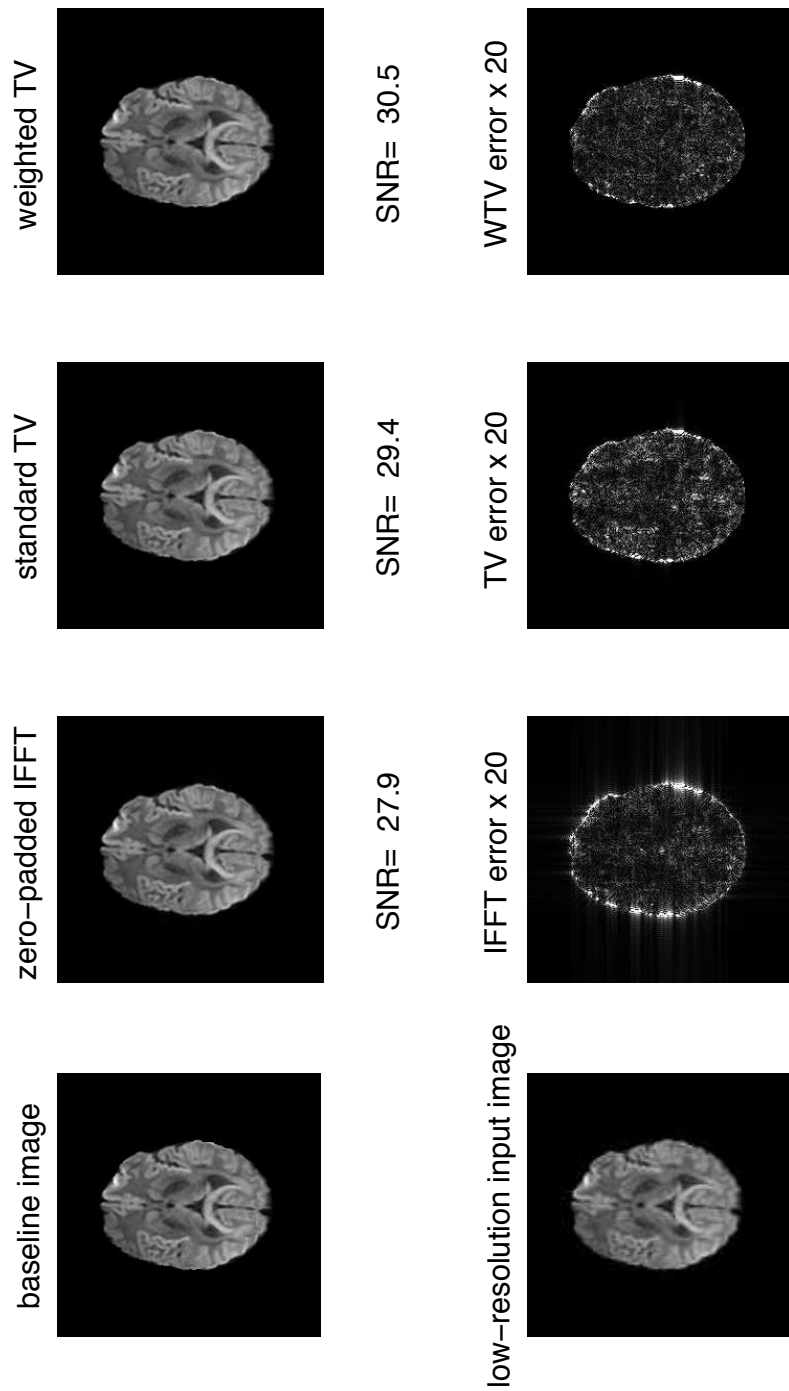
Reconstructed first gradient component of a typical DWI subject using 3 different methods. The SNR value is provided for the result of each method demonstrated in the first row. The second row shows the low-resolution image, by a factor of 2, and the difference image between each reconstructed image and the original high-resolution baseline image, that is magnified by 20 times. The higher SNR value for the developed weighted-TV approach indicates better reconstruction results for the gradient components as well.
